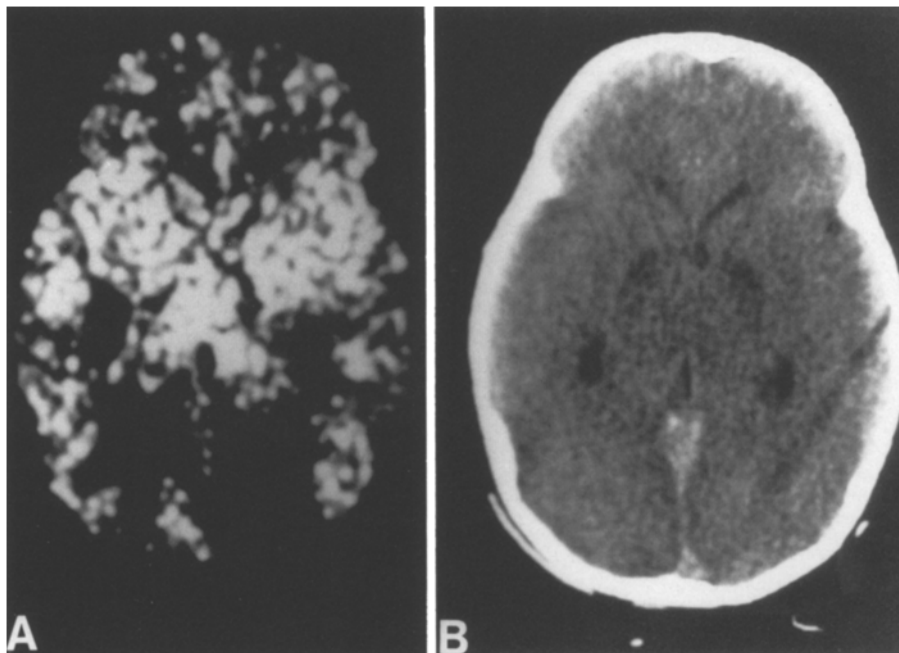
A Xenon CT flow map showing bilaterally increased densities in the region of the globus pallidus and bilaterally decreased densities in the occipital region. These findings suggest hyperemia in the globus pallidus and decreased blood flow in the distribution of the posterior cerebral arteries. B CT scan at same level as flow map in Fig. 1 A showing decreased attenuation coefficients in the area of the globus pallidus bilaterally and no evidence of infarction in the regions of distribution of the posterior cerebral arteries
